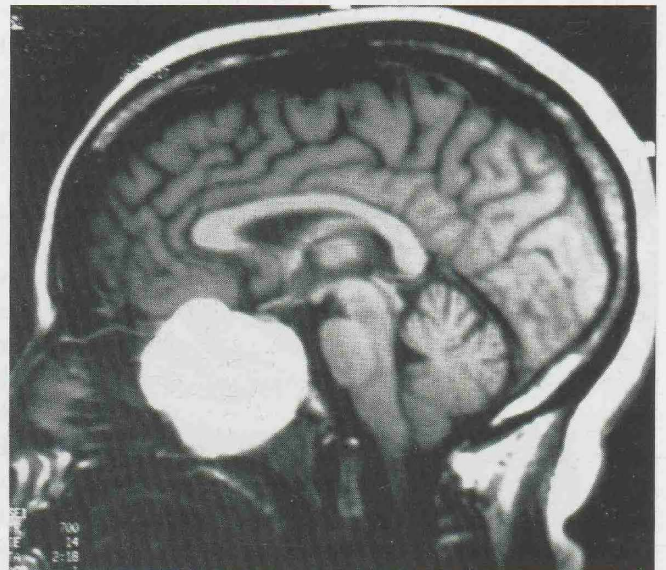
Sagittal MRI-view revealing a mucocele of the ethmoid sinuses with extension to the subdural space of the anterior cranial fossa.
